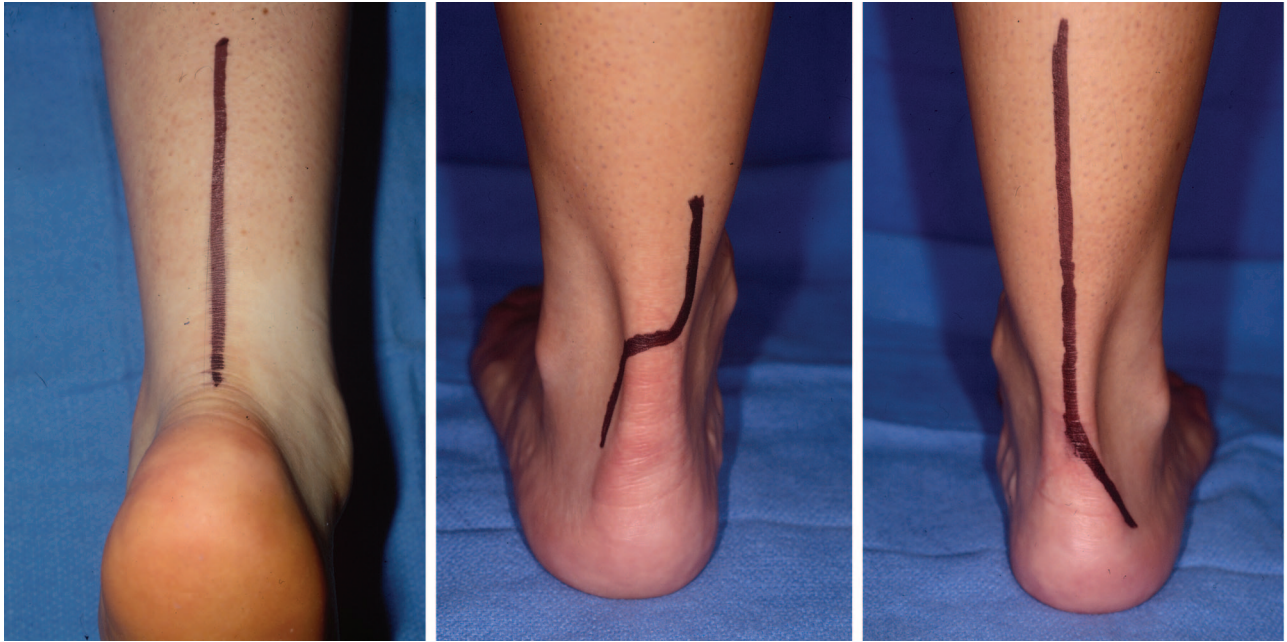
Incisions over the Achilles tendon are the safest if they are made along the midline that divides the peroneal angiosome from the posterior tibial angiosome (*left*). If there is a good Doppler signal over the posterior tibial artery and the calcaneal branch of the peroneal artery, an S-shaped incision can be made starting proximally and medially and finishing laterally and distally, to avoid the sural nerve and lesser saphenous vein (*center*). Finally, if the incision has to continue distally to the level of the posterior heel, it should curve laterally along the posterior heel pad glabrous junction (*right*).
